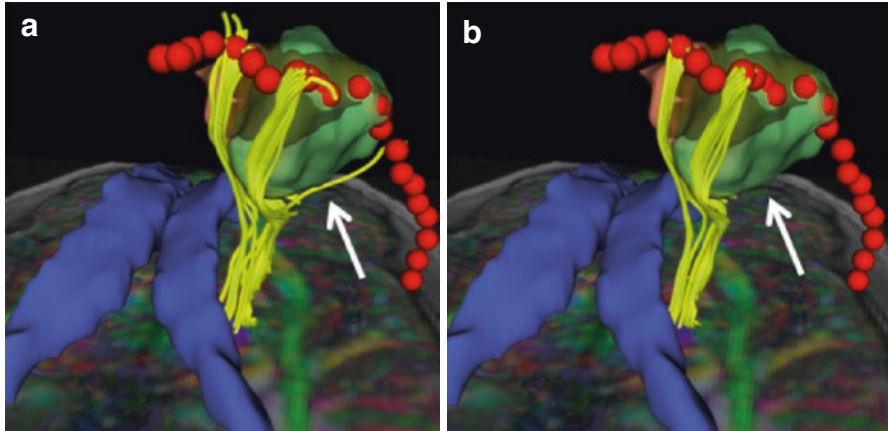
Impact of fractional anisotropy (FA) threshold on tractography results. The figure shows a dual 3D posterior view of the tractography reconstruction of pyramidal fibers (yellow) adjacent to a 3D surface model of an oligodendroglioma WHO grade II (green) and surgical cavity (brown). The tracts are seeded from pre-central gyrus sites (red spheres). Two different FA threshold values are used to terminate the tracking process: (a) FA = 0.10, (b) FA = 0.15. A peritumoral fiber ventral to the lesion is detected by the algorithm when the FA threshold is set to 0.10, and is not detected when the FA threshold is set to 0.15 (white arrow). An axial directionally encoded color map overlaid on a T1-weighted image and a 3D surface model of part of the lateral ventricles (blue) are displayed for anatomical reference
